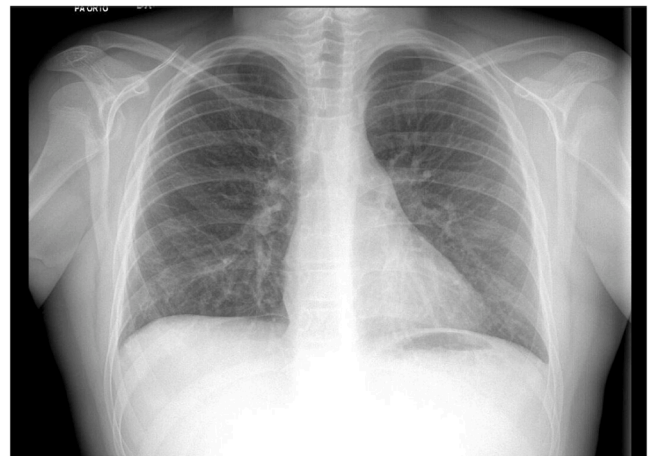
Follow-up anteroposterior chest X-ray obtained 4 months after discharging. It shows subtle opacities in the right lower lobe likely representing scarring.
